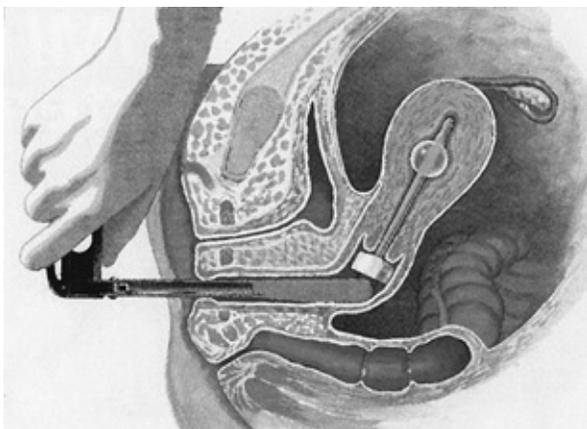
RUMI uterine manipulator (Cooper Surgical, Shelton, CT).
